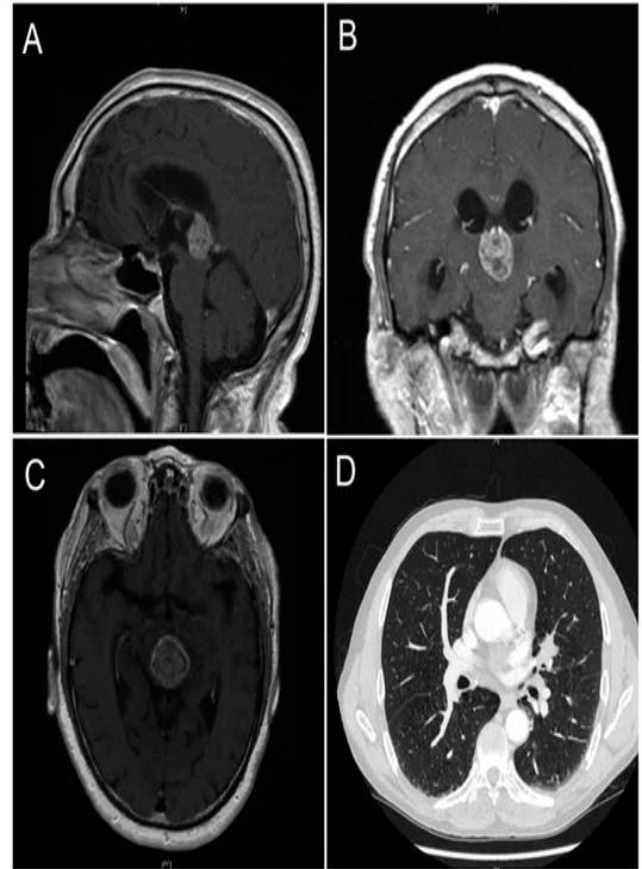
Pineal metastasis from lung adenocarcinoma. Brain MRI sagittal (A), coronal (B), and transverse (C) sections show the pineal gland metastatic mass. Computed tomography shows a lung nodule over the left hilar region in the lower right corner (D). Image from Abdallah et al. (2020)-Ochsner Journal.
